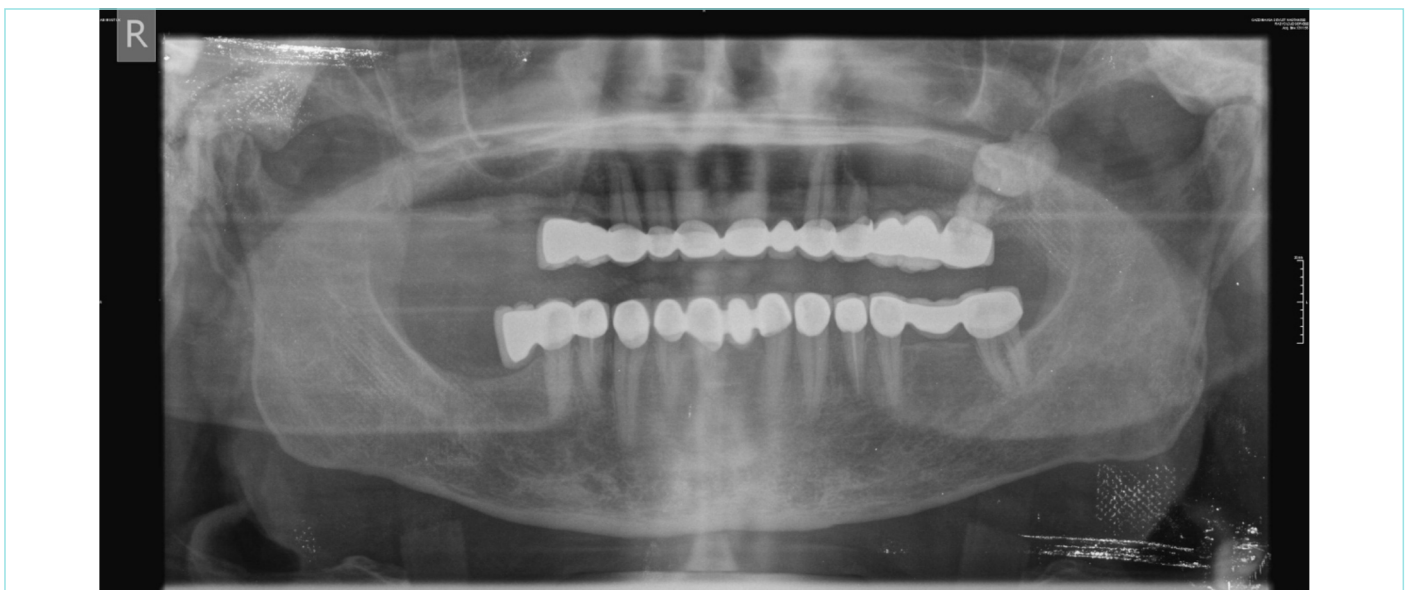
Panoramic radiograph of the lesion.
